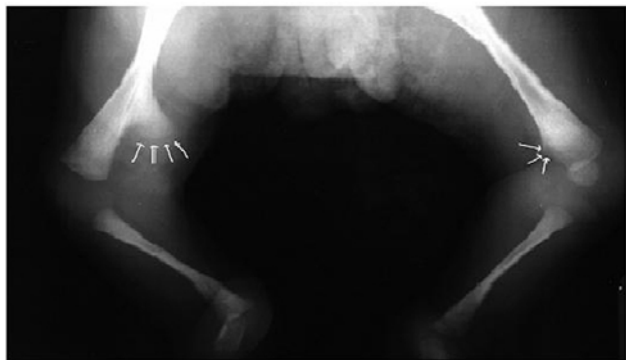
Anteroposterior radiograph of the lower extremities showing distal femoral duplication (white arrows) and absence of fibular bone.
